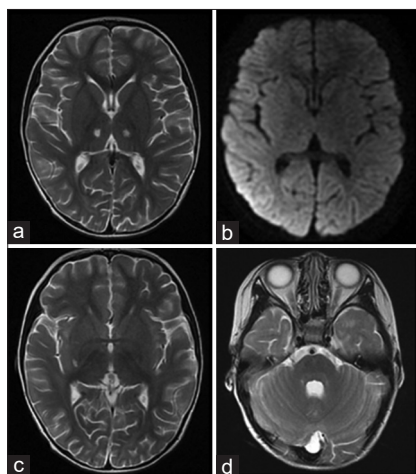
Two weeks after treatment, an MRI of the brain (a and b) showing no obvious swelling in the bilateral dorsal thalamus, obvious reduction in the scope of the lesions, and no limited diffusion. (c and d) Lesions of the right putamen, cerebellar vermis, and bilateral cerebellar hemispheres are significantly reduced. MRI = magnetic resonance imaging
